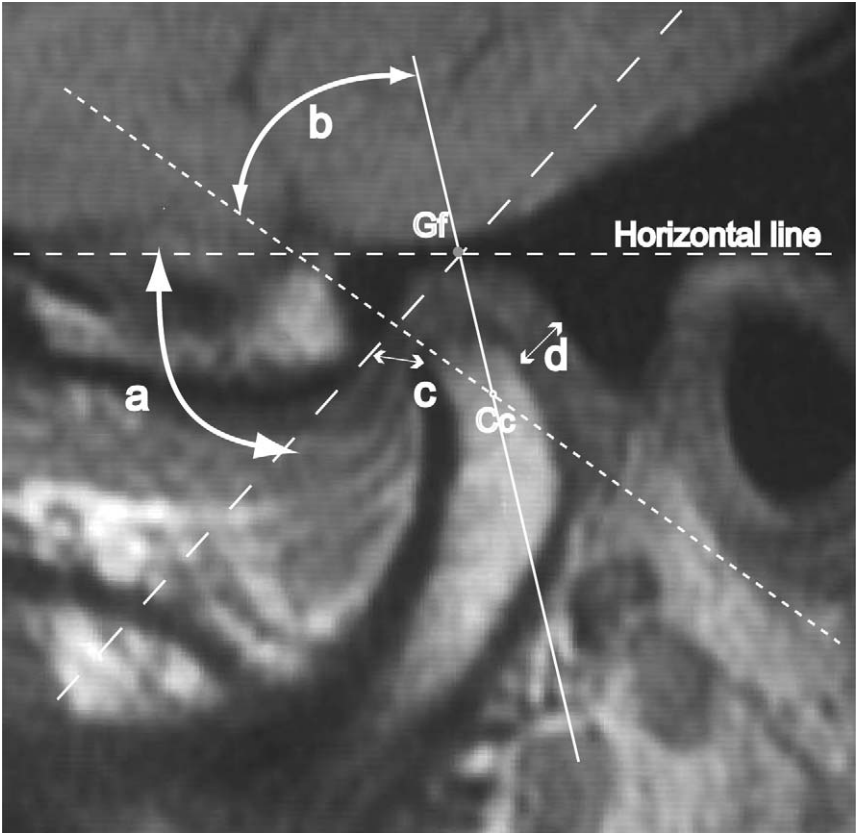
Measurements of the temporomandibular joint on MR images. (Gf) Uppermost point of the roof of the glenoid fossa. (Cc) Center of the condylar head. (a) Eminence slope angle between the horizontal reference line and a line from the Gf to the anterior slope of the glenoid fossa. (b) Disk position angle between the line from the Gf to the Cc and the line from the posterior edge of the disk to the Cc. (c) Anterior joint space. (d) Posterior joint space.
